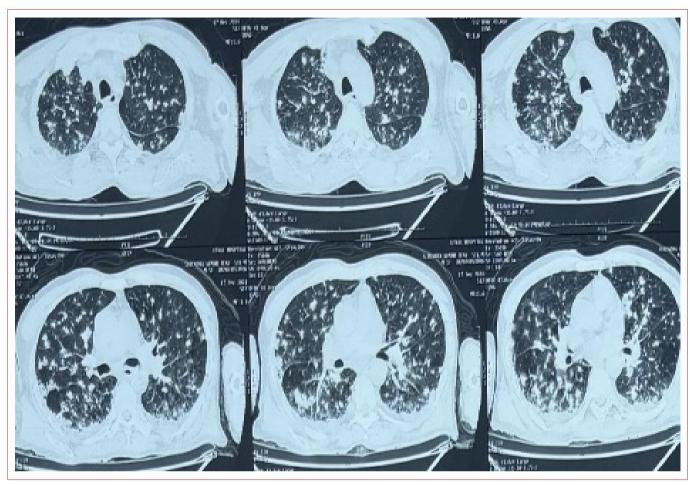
Ground-glass opacity and nodular opacity on high-resolution computed tomography (HRCT) of the chest in Case 1, suggestive of bacterial infection, tuberculosis, or melioidosis.
